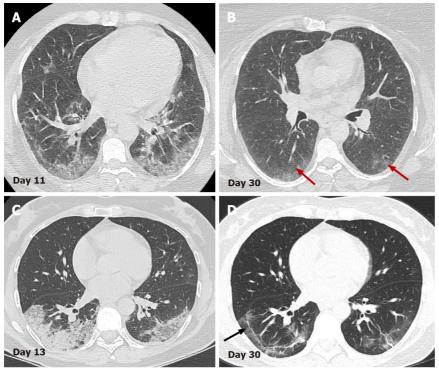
Serial axial computed tomography images. Serial axial computed tomography images in two different patients show gradual decrease of GGO and consolidations in the late stage of disease (B) and (D). In patient 1 (A) and (B) advanced resorption of the abnormalities is seen with very low density GGO at the sight of previous lung changes (red arrows). In patient 2 (C) and (D) architectural distortion with fibrous bands parallel to the pleura (black arrow) and traction bronchiectasis are visualized (arrowheads).
